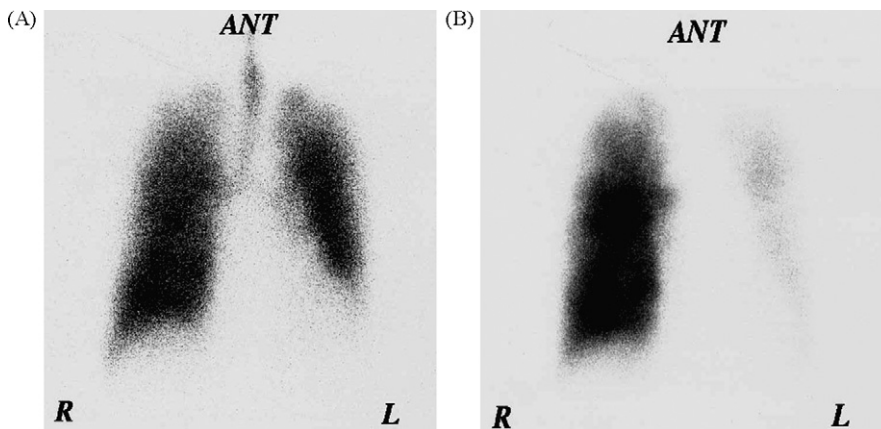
Pulmonary perfusion scans by scintigraphy showed a decrease in perfusion through most of the left lung that mismatched a pulmonary ventilation scan. (A) ventilation scan, (B) pulmonary perfusion scans.
